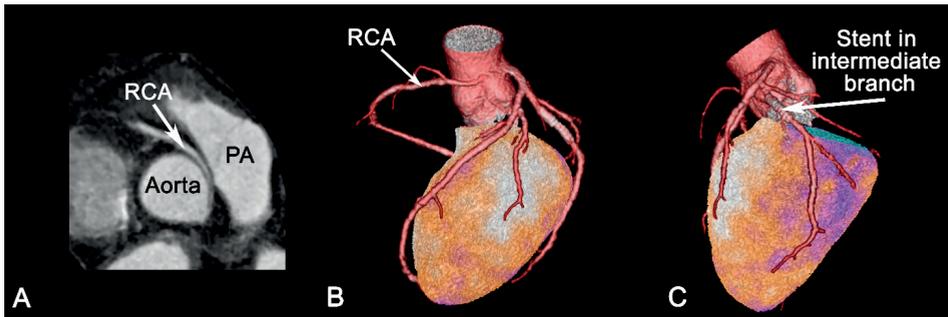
Fused CCTA/PET-MPI of a patient with a single left coronary artery. CCTA revealed a single left coronary artery (i.e. patient no. 5) with an intramural and interarterial course of the anomalous right coronary artery (A). Fused CCTA/PET-MPI (using the stress dataset) showed an inferolateral scar matching the perfusion territory of the previous stented non-anomalous intermedius branch with concomitant CAD (B, C). CCTA = Coronary computed tomography angiography; PET-MPI = Positron emission tomography myocardial perfusion imagin
